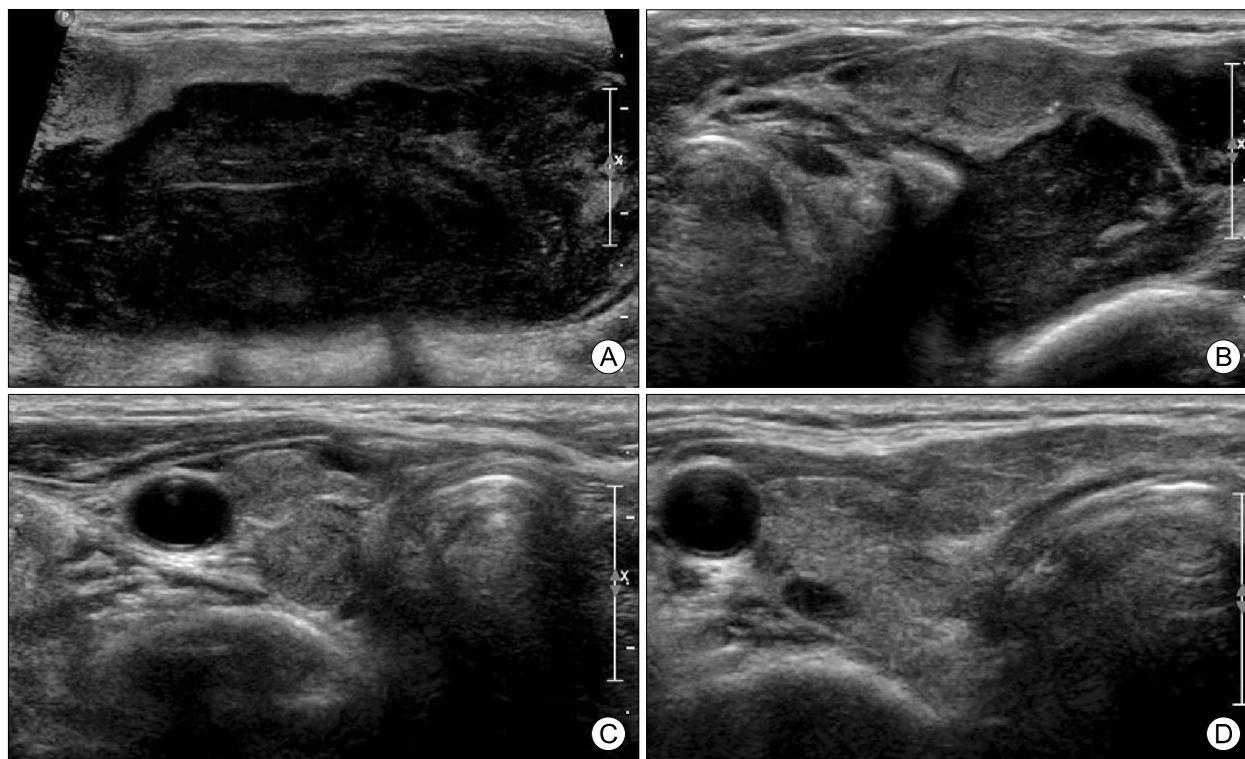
Initial ultrasonography of thyroid. A huge lobulated contoured hypoechoic solid mass in left thyroid gland, measured 6.4×5.4×3.0 cm (A), isoechoic solid mass with calcifications in left thyroid gland upper pole, measured 1.1×1.1×0.6 cm (B), isoechoic solid nodule in right thyroid gland lower pole, measured 0.9×0.8×0.7 cm (C), hypoechoic solid nodule in right thyroid middle lobe, measured 0.7×0.5×0.3 cm (D).
